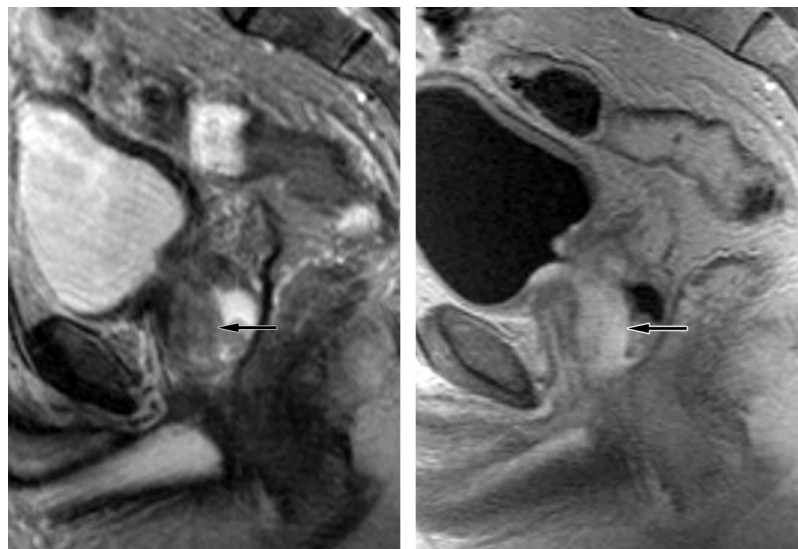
Urothelial carcinoma, or transitional cell carcinoma, of the prostatic urethra diagnosed at transurethral resection of the prostate in a 55-year-old man. MR imaging of the pelvis was ordered to evaluate for metastatic disease after BCG infusion therapy. Sagittal T2-weighted (a) and contrast-enhanced T1-weighted (b) MR images show an infiltrative tumor located predominantly in the anterior aspect of the gland. The tumor has a higher T2 signal intensity (arrow on a) than that of muscle and enhances avidly (arrow on b) after administration of gadolinium-based contrast material.
